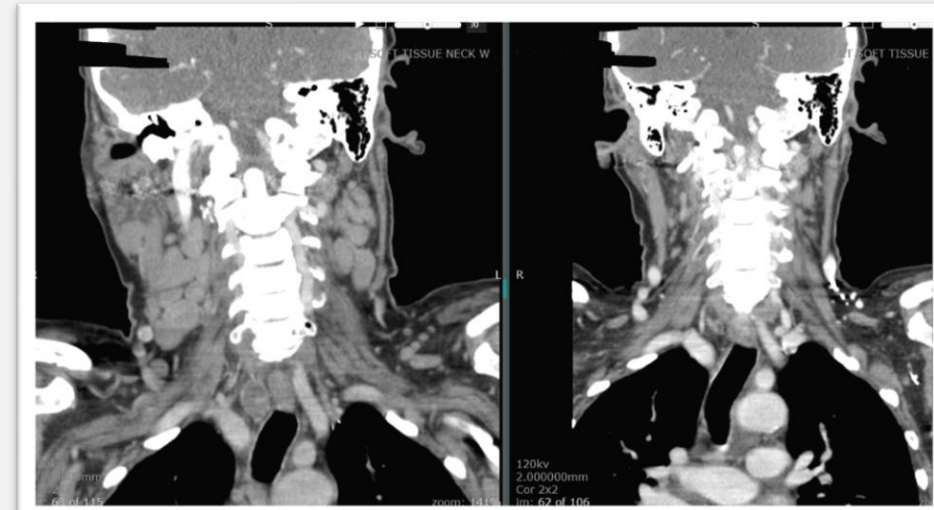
CT soft tissue of the neck with interval improvement in cervical lymphadenopathy after treatment (4mo later). The first CT scan also showed a mass in the right orbit compatible with intraorbital lymphoma and also prominent nasopharyngeal adenoidal tissues compatible with lymphoma.
